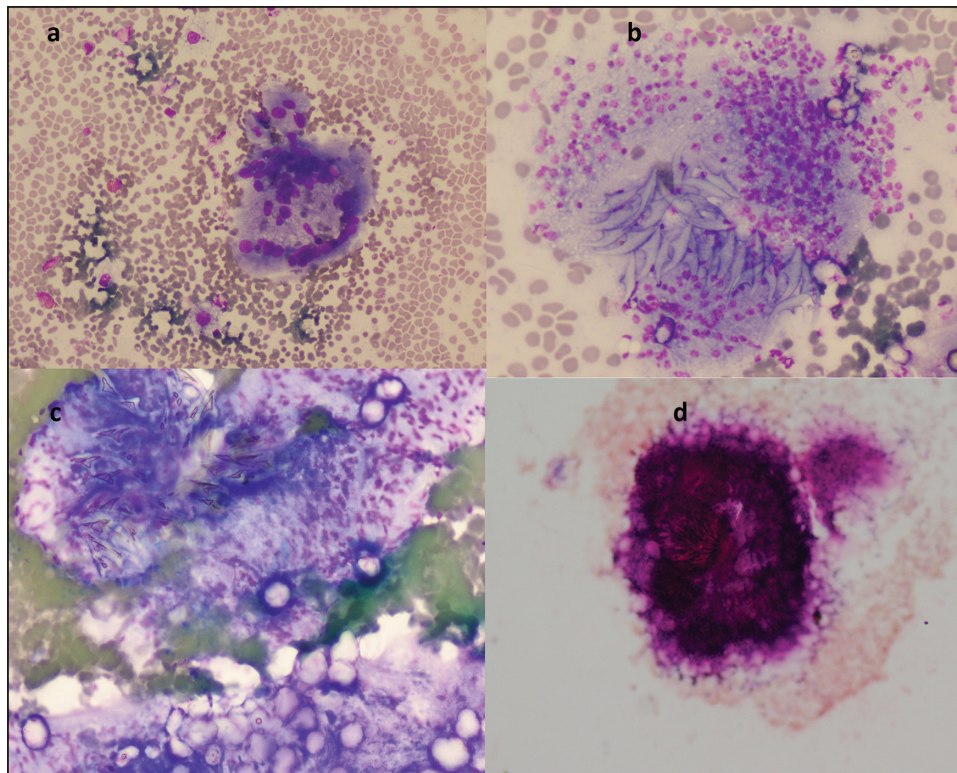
(a) CT-guided fine needle aspiration cytology lung showing reactive giant cells with few macrophages, eosinophils, and lymphocytes in a hemorrhagic background (May–Grünwald Giemsa; $\times 40$). (b–d) FNAC lung smears showing hydatid cyst brood capsule, scolex, hooklets, and endocyst membrane. CT = computed tomography, FNAC = fine needle aspiration cytology
